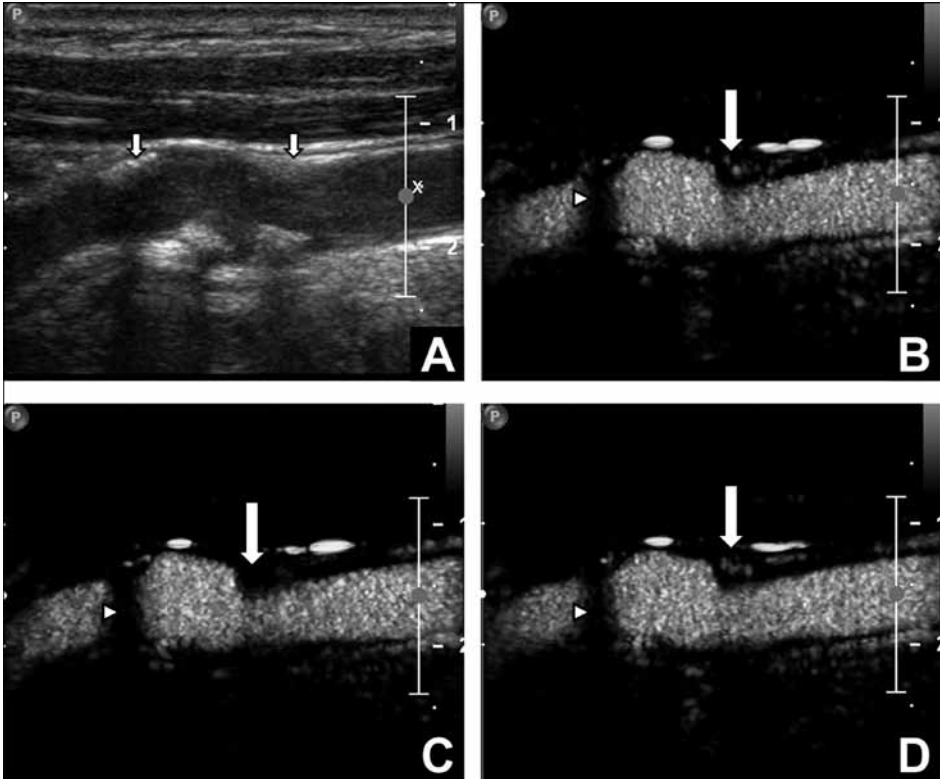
Identification of intraplaque neovascularization by contrast-enhanced ultrasound (CEUS) scan. Carotid artery B-mode ultrasound (A), and CEUS (B-D) acquired at three consecutive time points. Atherosclerotic plaques are present (small arrows) in the proximal part and distal part of the bulb. The distal plaque contains a calcification, identifiable by the shadowing (B-D: arrowheads). The highly enhanced regions (B-D) on the left and right side of the arrow are saturation artifacts. Panel (B) was acquired 0.5 seconds before a high mechanical index flash to destroy the contrast given. Contrast enhancement can be observed in the plaque (large arrow). Panel (C) was acquired 1.5 seconds after the flash, the intraluminal contrast has been replenished quickly, while the plaque enhancement has disappeared (large arrow). Panel (D) was acquired 6 seconds after the flash and shows the contrast microbubbles in the plaque (large arrow) indicating the presence of intraplaque neovascularization (image acquisition described in Figure 1 legend).
